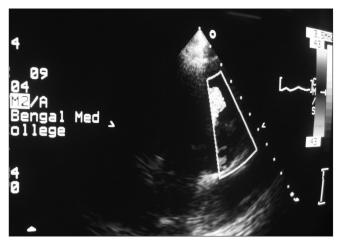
Parasternal short axis view of echocardiography showing pulmonary valve stenosis
